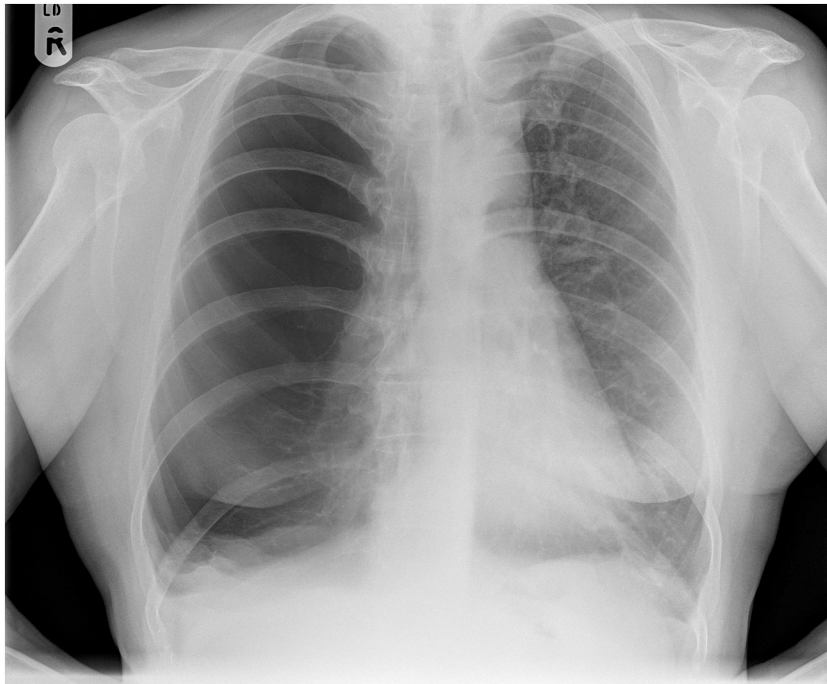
Chest radiograph in 2013 showing small basal right bulla.
